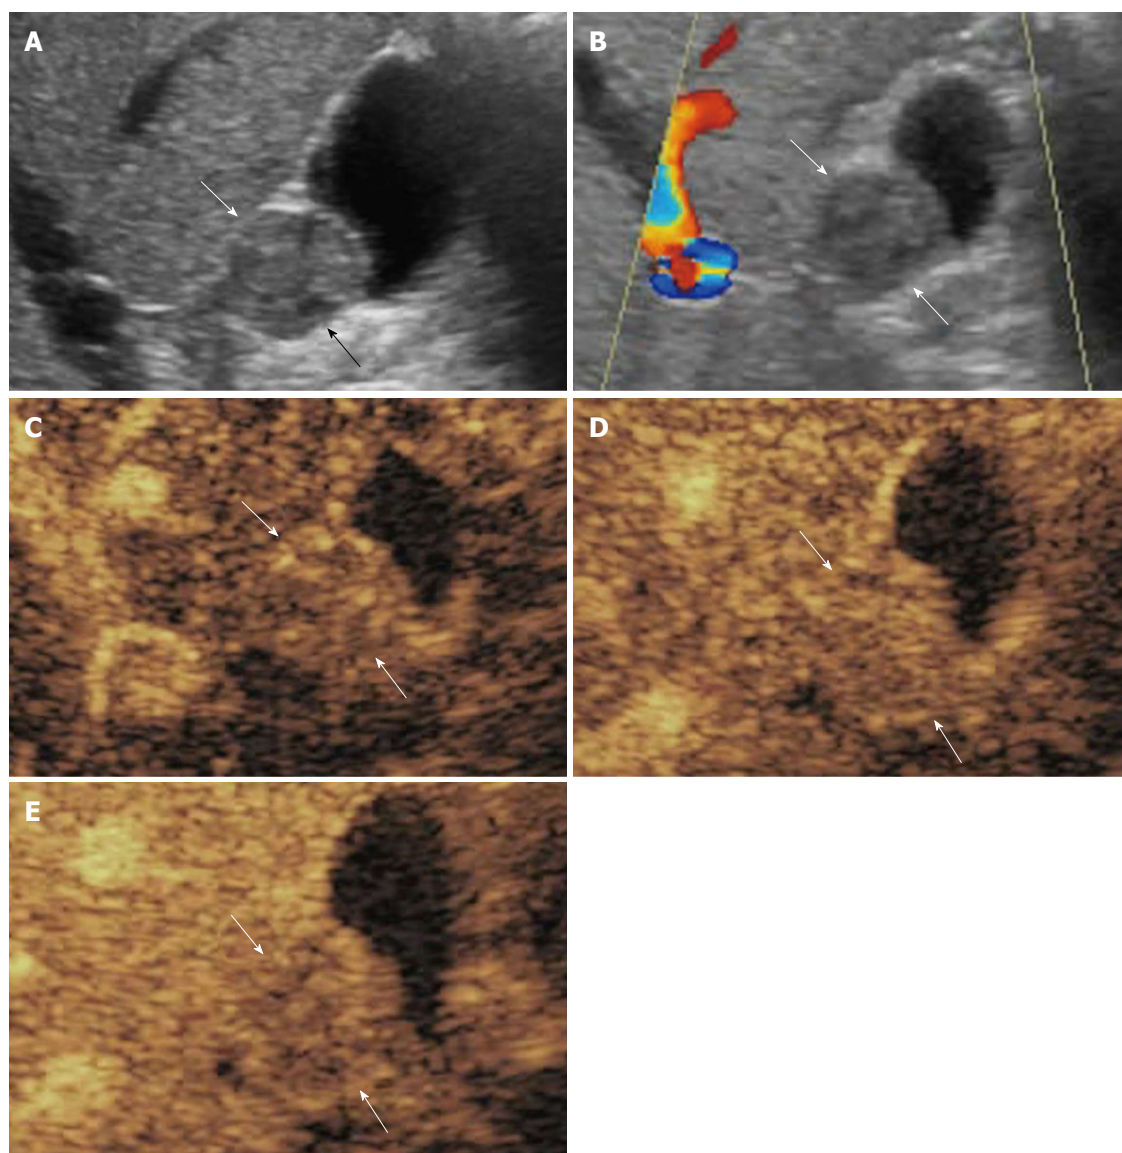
Ultrasound and contrast-enhanced ultrasound imaging. A: Conventional ultrasound shows a lesion (arrows) sized 2.1 cm in diameter in the gallbladder; B: Color Doppler ultrasound shows no blood supply in the mass (arrows); C: The lesion (arrows) shows hyper-enhancement 21 s after contrast agent injection; D: The lesion (arrows) shows iso-enhancement 34 s after contrast agent injection; E: The lesion (arrows) shows slight hypo-enhancement 54 s after contrast agent injection.
